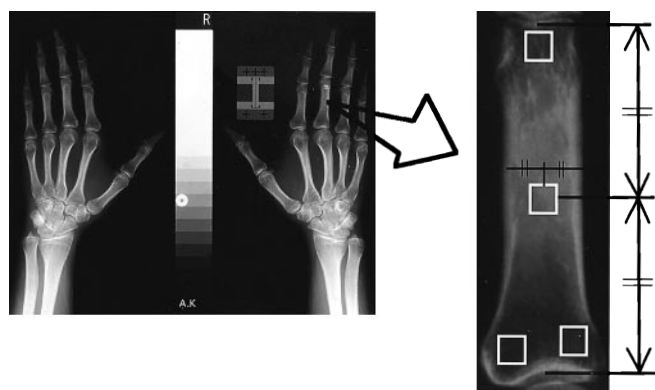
Preparation of picture data from a radiograph. The radiograph was scanned, and the right third proximal phalanx was magnified nine times. Four squares, 20 × 20 pixels each, were set, one at the midpoint of the diaphysis and three at the distal and proximal epiphyses. Care was taken not to attach a square to a cortical bone itself
